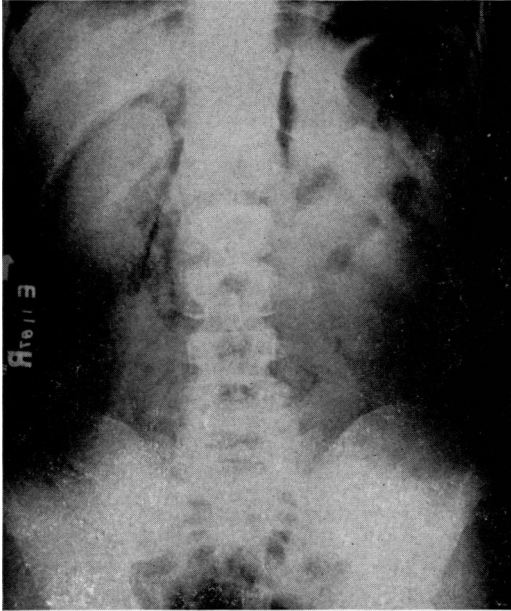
Roentgenogram of the abdomen in erect positions taken 14 hours after injury, showing marked retroperitoneal air around right kidney and both psoas shadows.
